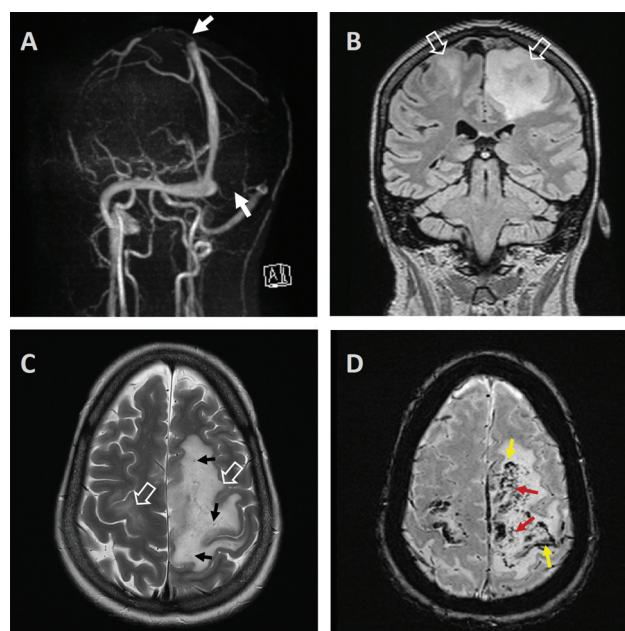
Magnetic resonance images demonstrate cerebral venous thrombosis and venous infarctions. (A) Lack of flow signal from thrombosis in the superior sagittal sinus and the left transverse sinus (white arrows) is evident on the three-dimensional (3D) model generated from a phase contrast venography. (B) High signal from edema in venous infarctions (open white arrows) is demonstrated on the coronal fluid-attenuated inversion recovery (FLAIR) sequence. (C) High signal from edema (open white arrows) and low signal from microhemorrhages (black arrows) in venous infarctions can be seen on this axial T2 turbo spin echo sequence. (D) Signal loss from deoxygenated stagnant venous blood (yellow arrows) and from microhemorrhages (red arrows) on this thin (1.6 mm) axial minimum intensity projection (MinIP) reconstruction from susceptibility weighted imaging (SWI) sequence.
